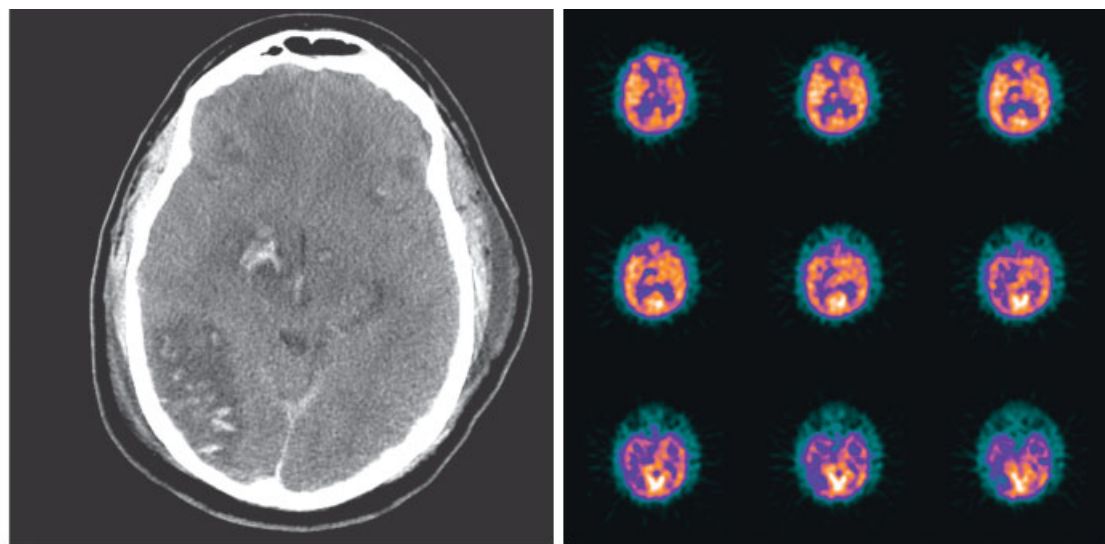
Neuroimaging in traumatic brain injury (TBI). Transaxial images from non-contrast head CT and single-photon emission computerized tomography (SPECT) images showing intraventricular hemorrhage and large parenchymal hematoma in right parieto-occipital area and hypoperfusion in the same area. (Image courtesy of Alan Siegel, Dartmouth Medical School, Nuclear Medicine.)
